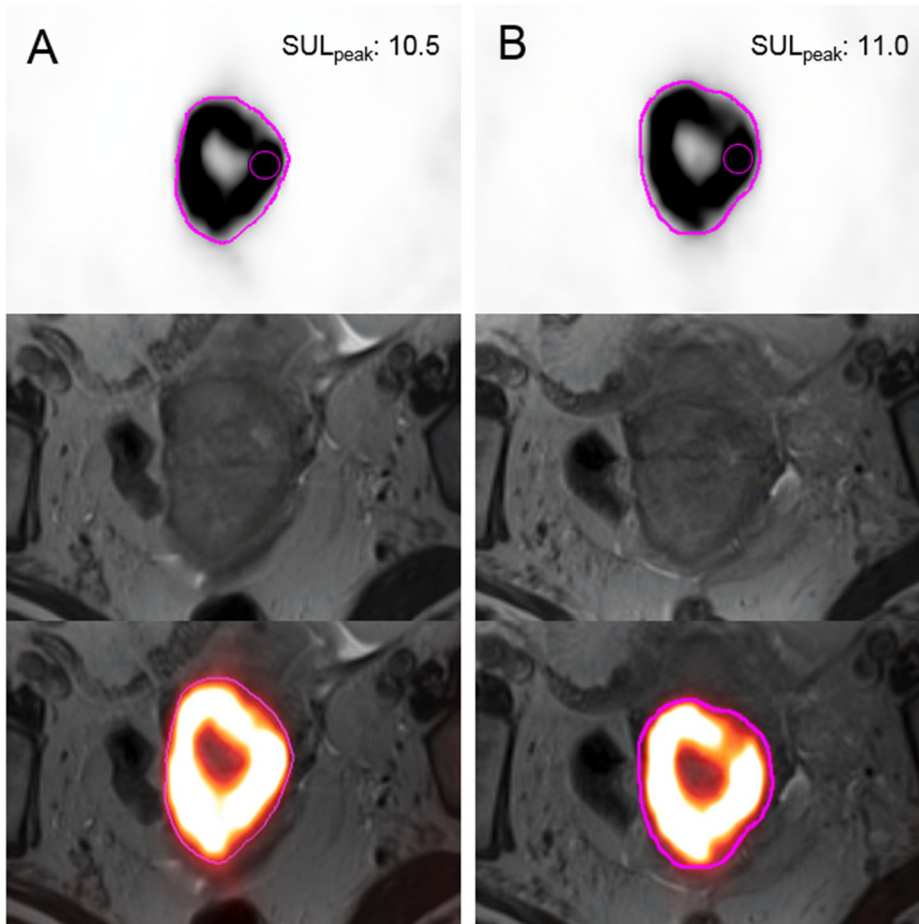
SUL_{peak} repeatability from PET image analysis. A 65-year-old woman with biopsy-proven squamous cell carcinoma of the cervix was imaged with 24 hours between session 1 (A) and session 2 (B). Transaxial PET images with manual whole tumor contours (pink), T2-weighted MR images, and fused PET/MR images are shown from top to bottom for each imaging session. Note the inter-session contour similarities. The SUL_{peak} (small pink sphere) was located in the same tumor region for both sessions, with similar values.
